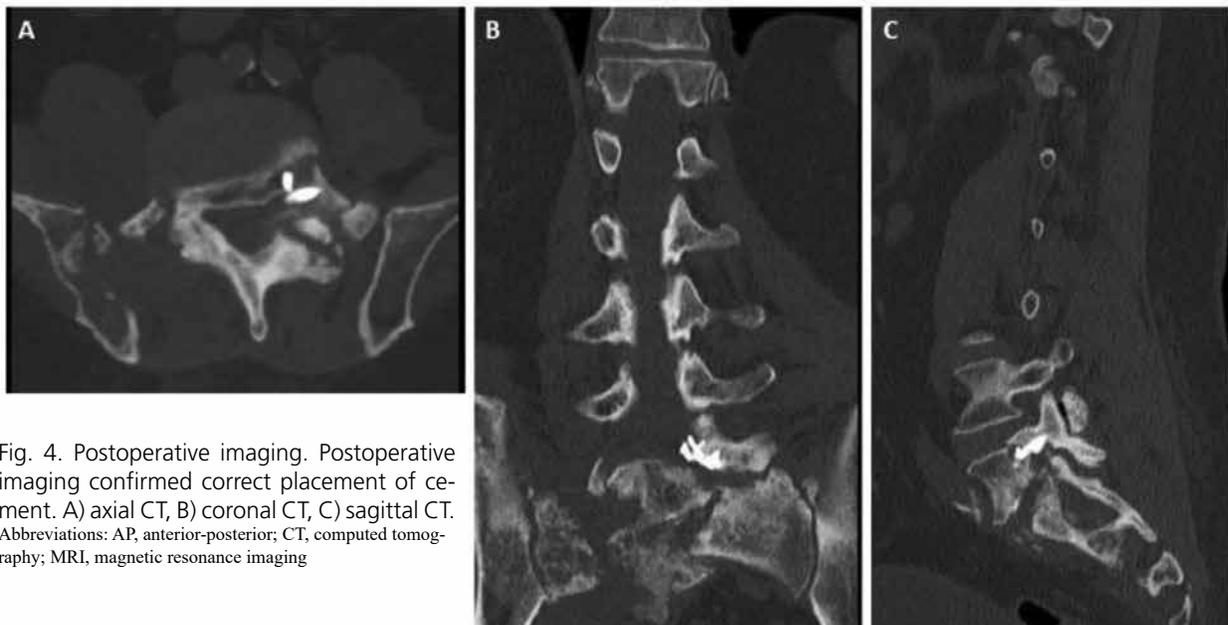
Postoperative imaging. Postoperative imaging confirmed correct placement of cement. A) axial CT, B) coronal CT, C) sagittal CT. Abbreviations: AP, anterior-posterior; CT, computed tomography; MRI, magnetic resonance imaging
